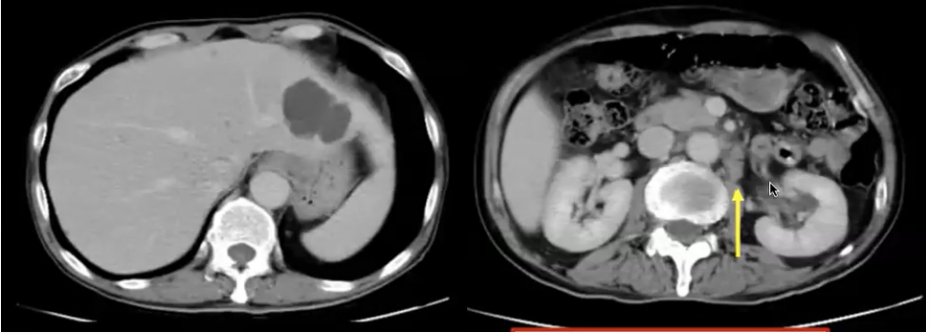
Abdominal CT images after treatment (in November 2021)
